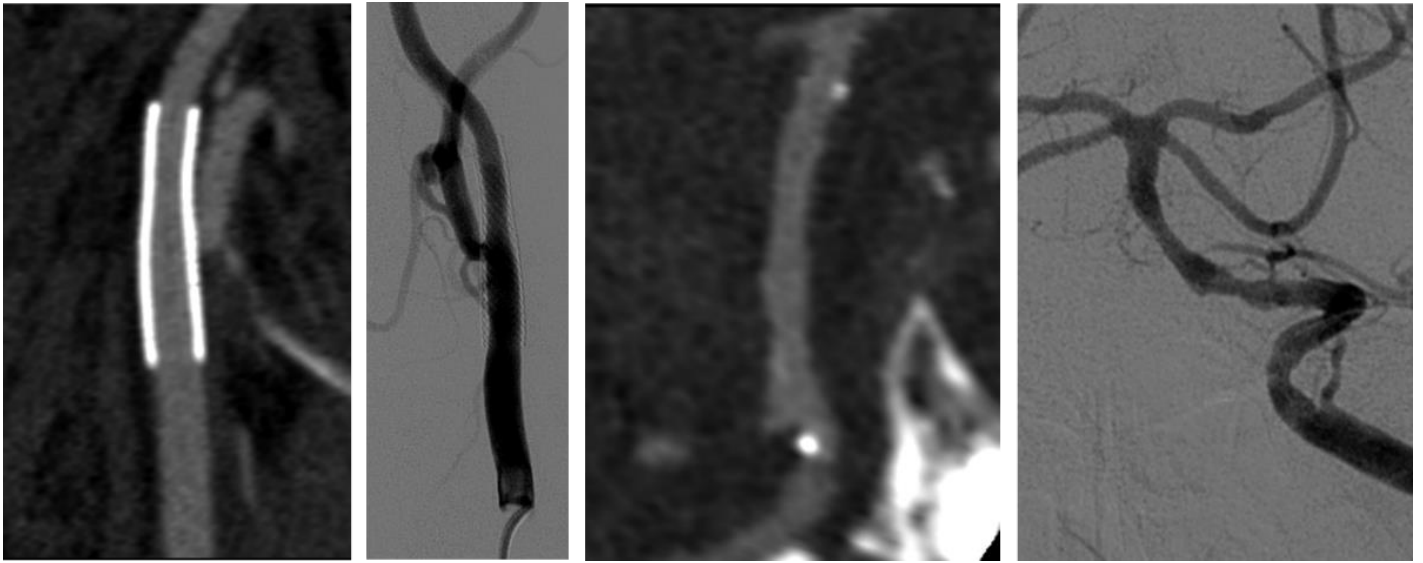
55-year-old male patient with symptomatic left ICA and BA stenosis, which were treated with balloon angioplasty and stenting. After 2 years of invasive follow up we performed CT angiography, which did not show any restenosis in neither location.
